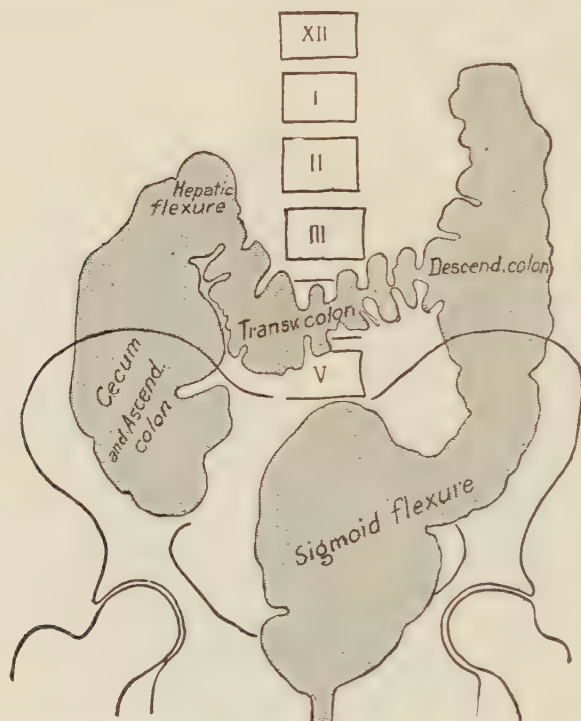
Radiographic view of the large intestine (Tuffier, Aubourg).
